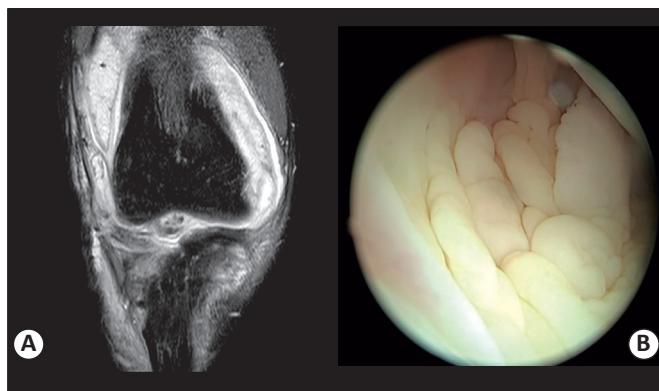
(A): Intensive synovial tissue hypertrophy; increased synovial fluid; soft tissue edema expanding to the suprapatellar, infrapatellar, and popliteal areas located around the knee; and post-contrast enhancement in magnetic resonance imaging. (B): Atypical synovial and septal thickening and white villous formation in the knee during arthroscopic examination.
